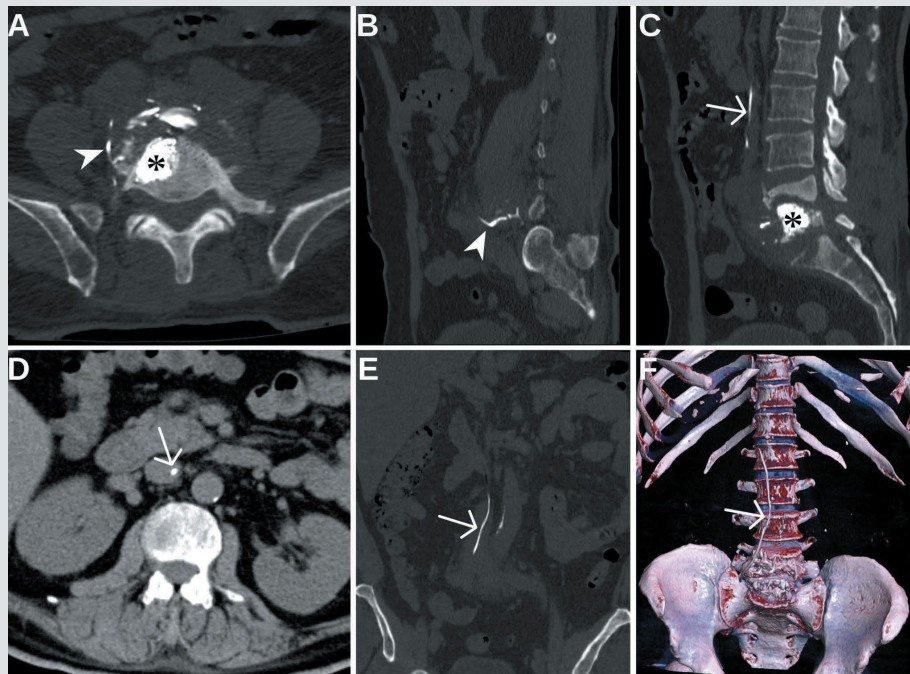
Non-contrast CT images of the lumbar spine in axial (A, D), sagittal (B, C), and coronal (E) planes, along with 3D reconstruction (F). Findings demonstrate status post right-sided vertebral augmentation of the L5 body using bone cement, with associated degenerative changes at the L4, L5, and S1 levels (asterisks). Hyperdense cement material is seen within the inferior vena cava (white arrows). A cement leakage tract extends from the paravertebral venous plexus into the inferior vena cava, ascending cranially up to the level of the L1 vertebral body (arrowheads).
